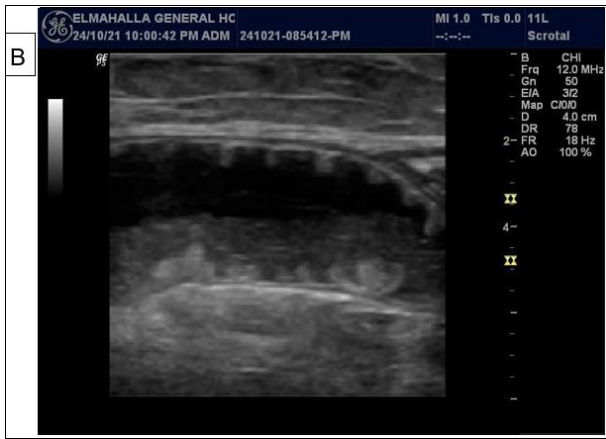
A & B: scrotal ultrasound revealed
